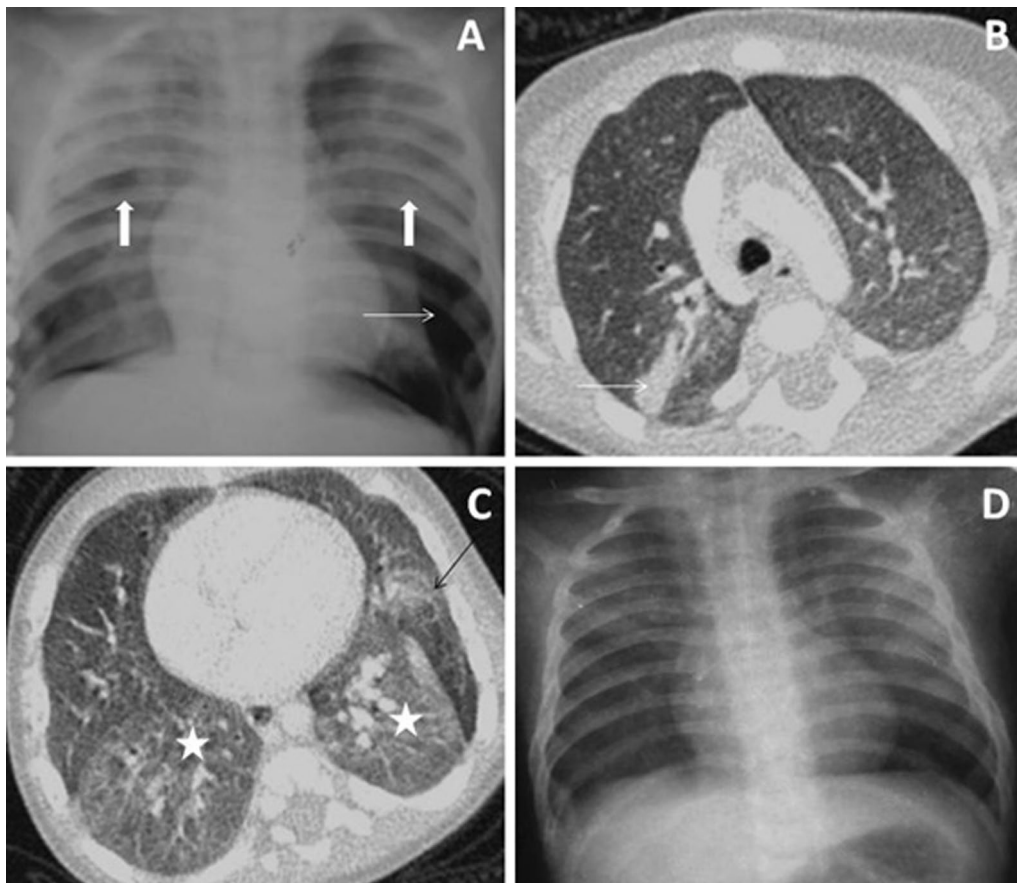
Bacterial Infection. An 18-month-old male child reveals consolidation/haziness in bilateral upper & mid zones (thick vertical arrows), with hyperinflation in left lower zone (thin horizontal arrow), on frontal CXR (A). CT chest (axial, lung window) shows subsegmental consolidation in RUL (arrow in B), GGO in bilateral lower lobes (asterisks) and consolidation with hyperinflation of lateral basal segment of LLL (arrow in C). Sputum could not isolate any microorganism. BAL isolated *Klebsiella* species. CD4 count was 406 cells/cu.mm. Patient responded to antibacterial antibiotics and improved clinically & radiologically (D) over a period of 4 weeks
